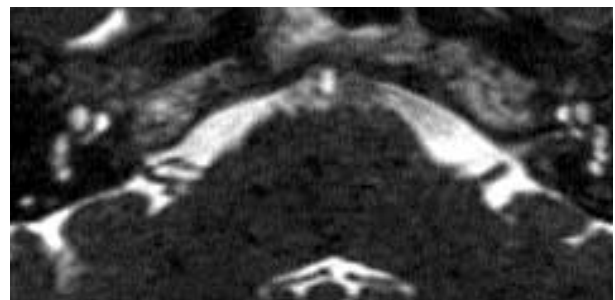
MRI assessment with T2 CISS sequence of the right acousticofacial nerve bundle a perpendicular contact and posterior distortion of the cochleovestibular nerve. (MRI, magnetic resonance imaging; CISS, constructive interference in study state.)
